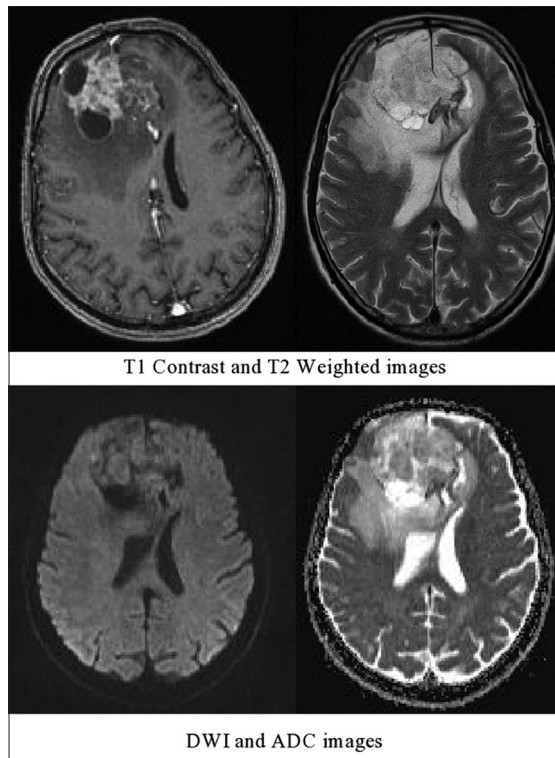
Glioblastoma multiforme. 56-year-old male presents with severe headache, giddiness, and vomiting since 3 months. Magnetic resonance imaging shows an ill-defined intraaxial enhancing mass. T1-weighted images hypointense (not shown here). T2-weighted images hyperintense lesion with multiple blooming on gradient images with cystic lesions within seen in the right frontal lobe. The enhancing solid portion of the lesion shows restriction on diffusion-weighted imaging (mean apparent diffusion coefficient of $0.44 \times 10^{-3} \text{ mm}^2/\text{s}$). Biopsy report: Glioblastoma multiforme
